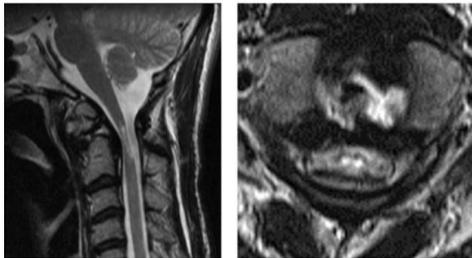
Cervical spine radiographs (A) and cervical spine CT (B) images showing an os odontoideum. Flexion and Extension radiographs (A) demonstrating an C1-C2 instability (Red circle). Cervical spine MRI (C) images showing an unstable C1-C2 region and spinal cord compression at C1-C2 level.
